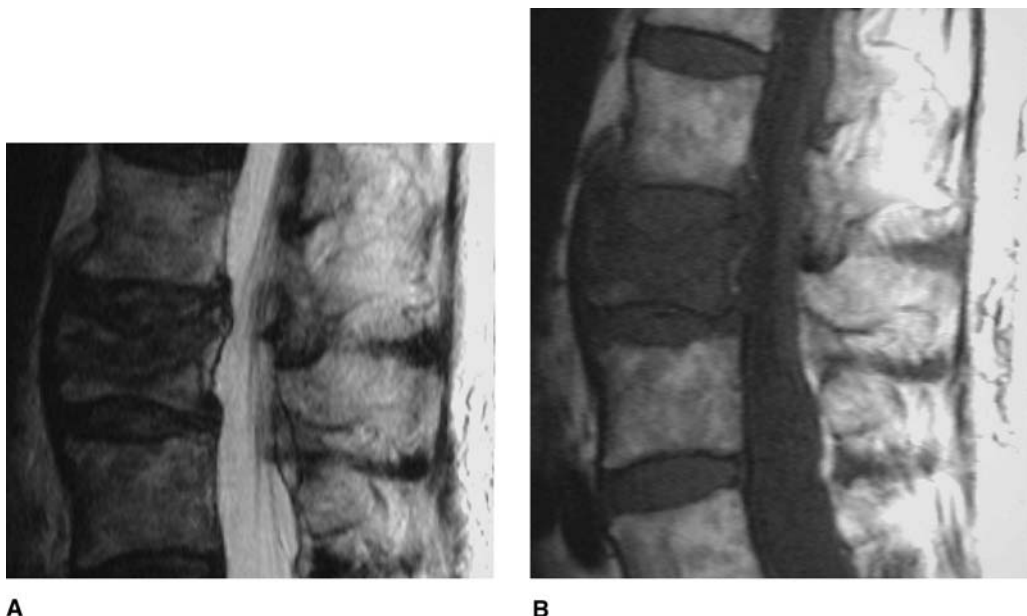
MR images (A, T₂-weighted; B, T₁-weighted) can demonstrate increased bone edema as well rule out fracture retropulsion into the canal.
